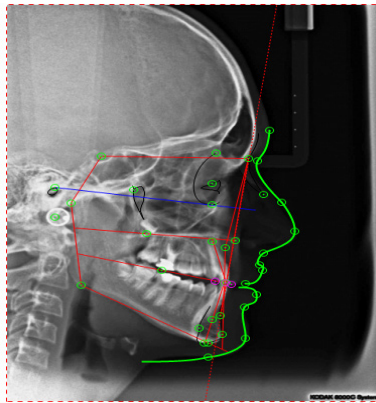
Lateral radiography and cephalometric analysis
